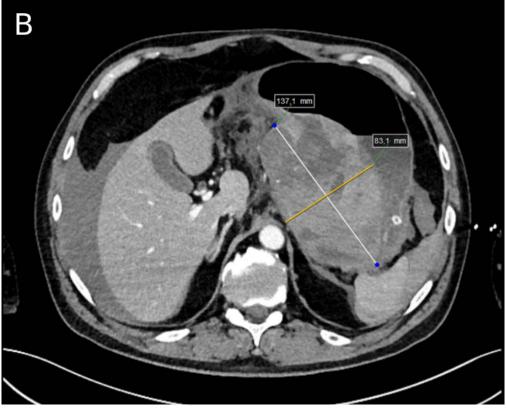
A. Changes in critical parameters overtime. T — beginning of transfusion of 4 units of packed red blood cells and 2 units of plasma). B. Computed tomography — hemorrhage in the omentum
